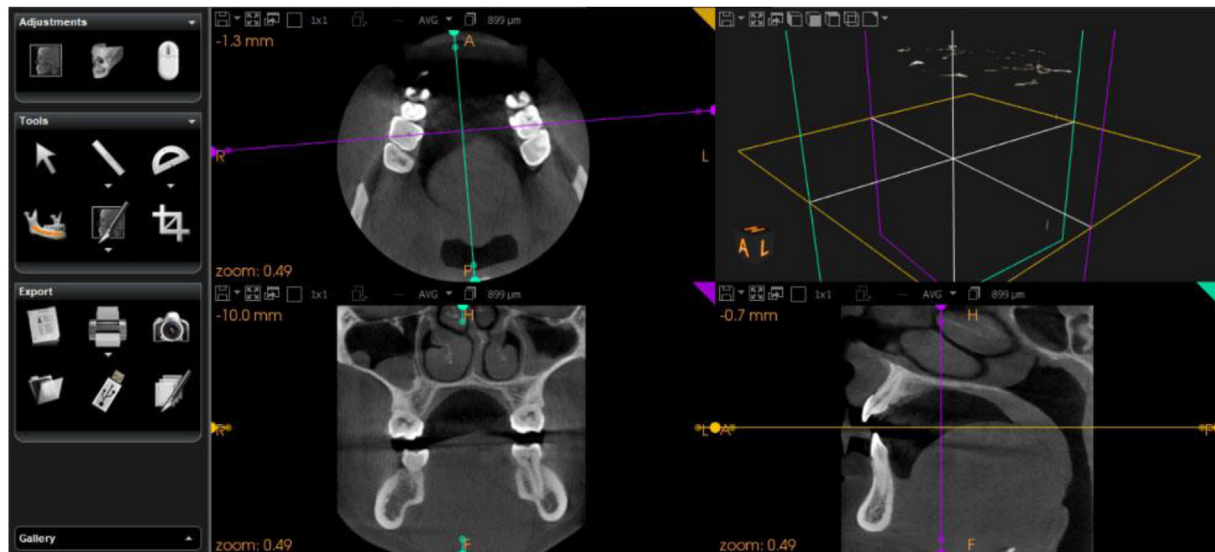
Coronal, axial, and sagittal sections of maxilla on CBCT.
